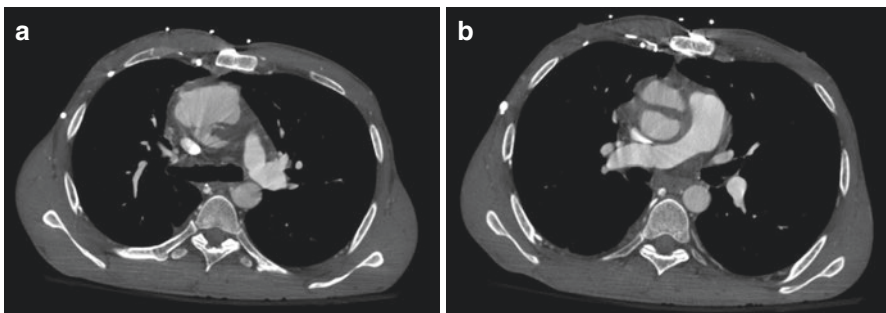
(a, b) Serial axial contrast-enhanced CT images (a, b) in a 43-year-old male with cystic fibrosis status post bilateral lung transplant demonstrate a rare complication of *Aspergillus fumigatus* infection of the mediastinum with subsequent mycotic aneurysm formation. Slight narrowing is seen at the site of anastomosis within both central pulmonary arteries, which is a typical finding
